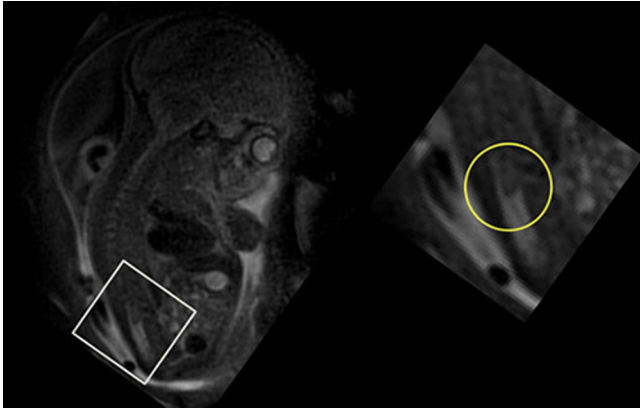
Box inset of fetal MRI is magnified to demonstrate short and blunted terminus of conus medullaris.
